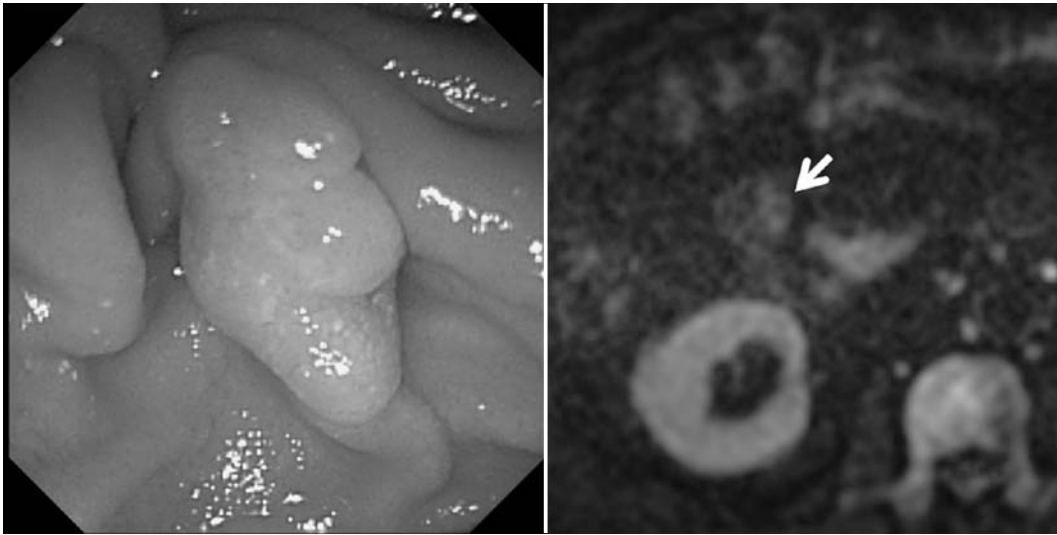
Endoscopy and diffusion-weighted magnetic resonance imaging of Case 13 (hyperplasia). The endoscopy showed a thick tortuous elevation with a relatively smooth surface in the ampulla of Vater (left). Diffusion-weighted magnetic resonance imaging only visualized the tumor, which was isointense relative to the adjacent duodenal wall (white arrow).
